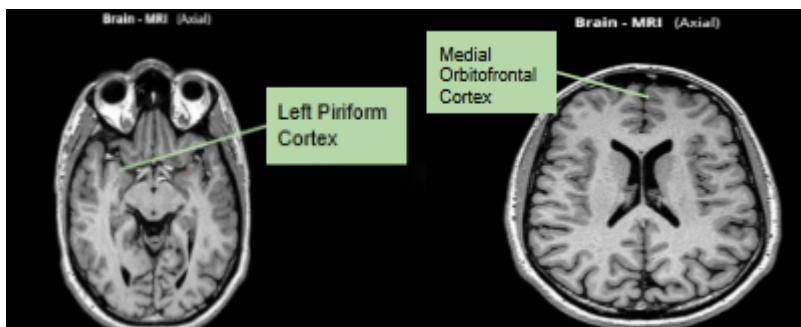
Areas of the brain associated with increased cortical thickness in congenital anosmia. Courtesy of IMAIOS © “Antoine MICHEAU, MD , Denis HOA, MD Authors' affiliations, Publication date: Aug 25, 2008, Anatomy of the brain (MRI) - cross-sectional atlas of human anatomy, <https://doi.org/10.37019/e-anatomy/163>
